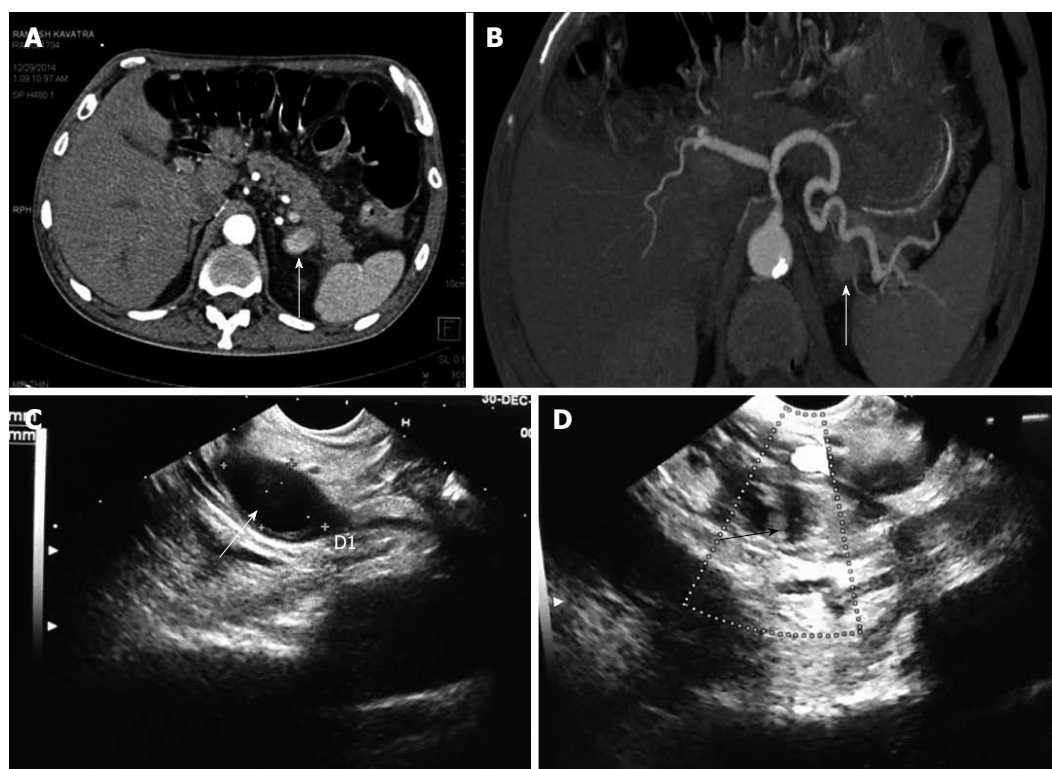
Chronic calcific pancreatitis with upper gastrointestinal bleed. A: Axial contrast enhanced; B: Axial MIP (3-D reformatted) CT images; C and D: Endoscopic ultrasound images. There is a pseudoaneurysm sac (arrow, A) in relation to distal body of the pancreas, in close relation to the splenic artery (arrow, B) and confirmed by endoscopic ultrasound (arrow, C) and subsequently managed by instillation of thrombin under EUS guidance with complete thrombosis of the pseudoaneurysm was achieved as revealed by the transformation of the previously anechoic lesion to an echogenic sac (arrow, D). CT: Computed tomography; MIP: Maximum intensity projection; EUS: Endoscopic ultrasound.
